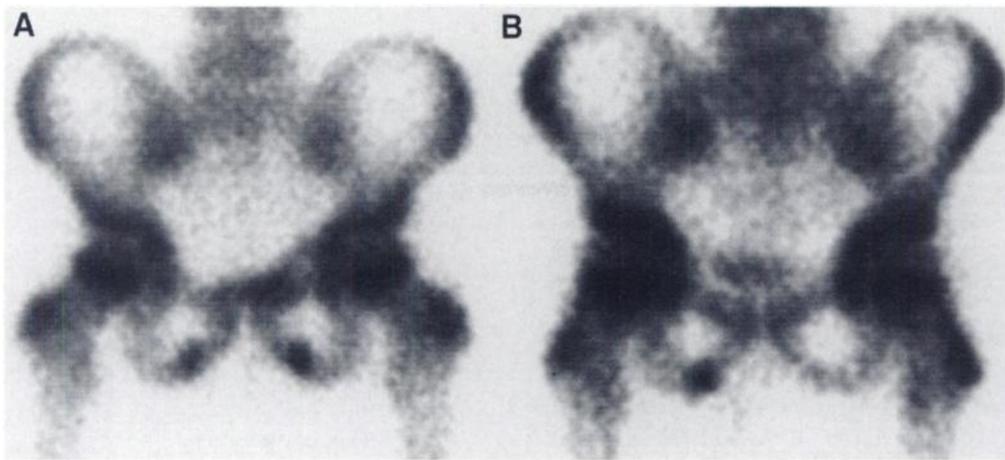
Normal ischiopubic synchondroses. The ischiopubic synchondroses of the 6-yr-old boy whose scintigraphic image is depicted in (A) appear as symmetric, well-defined foci of high tracer localization. The synchondroses of the 5-yr-old boy depicted scintigraphically in (B) have an asymmetric appearance.
